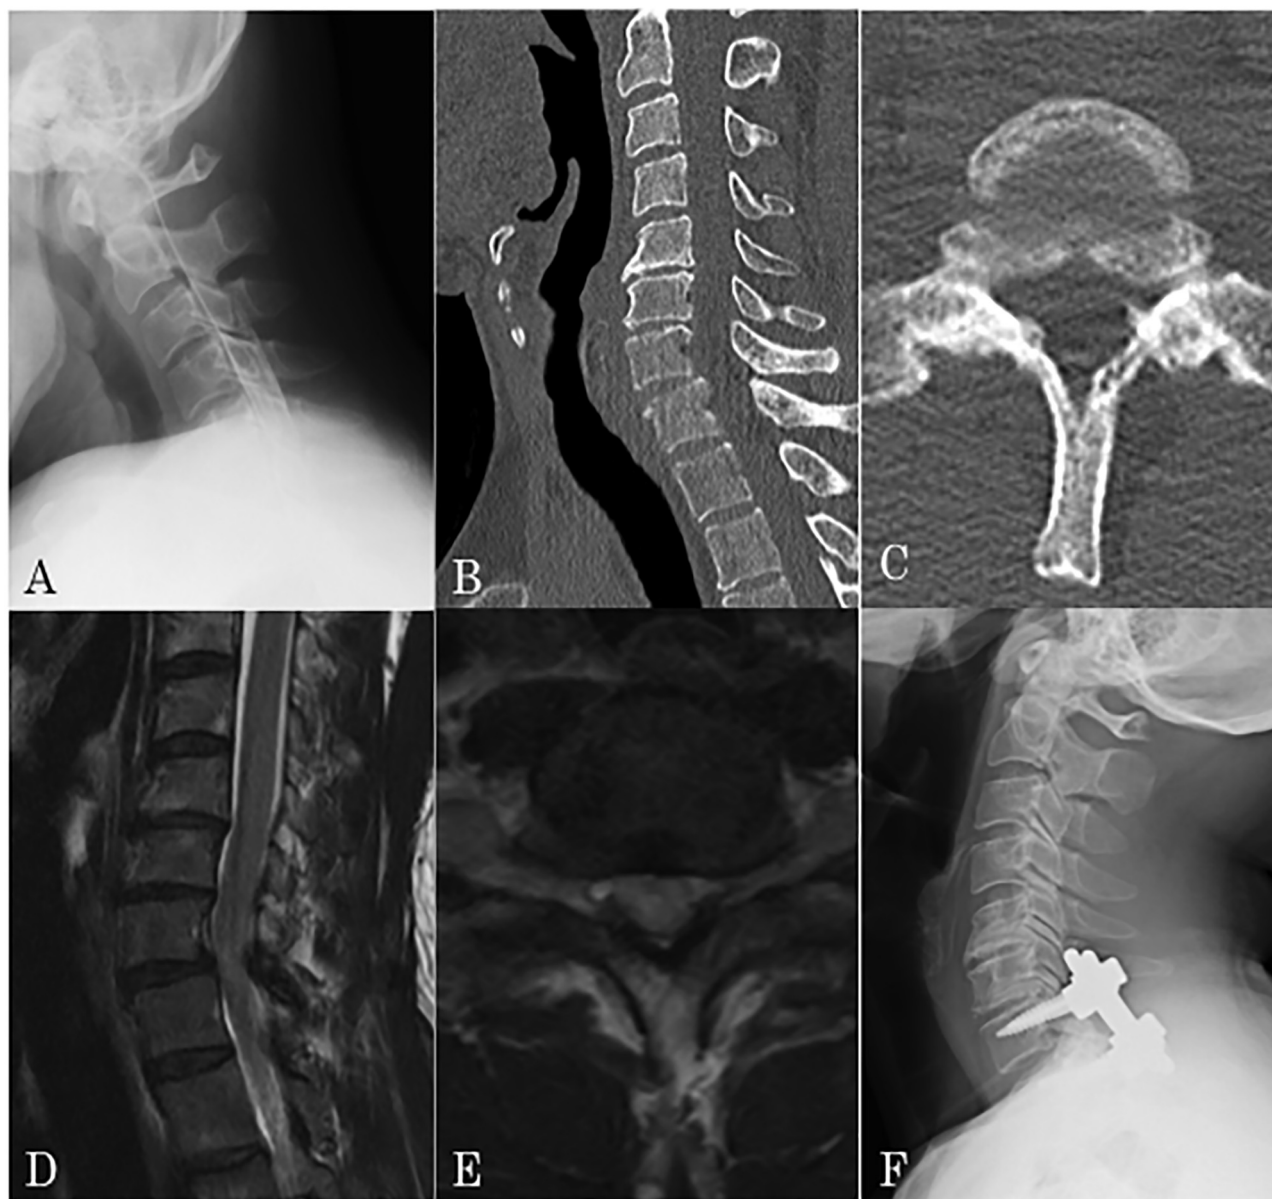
(A) Preoperative lateral view radiograph of cervical spine. Apparent abnormality could not be detected. (B) Sagittal reconstructed computed tomography (CT). (C) Axial image of CT-myelography at C7-T1 level. The spinal cord is compressed from both sides and shows atrophy. The C7-T1 facet joint indicates severe arthrosis with bony spur extending into the spinal canal. (D) Magnetic resonance imaging (MRI) T2-weighted sagittal plane. Spinal cord is compressed at C7-T1 level mainly from posterior. Note the intramedullary signal change at C7-T1 level. (E) Axial plane of MRI T2-weighted image. The spinal cord at C7 shows swelling with a region of slightly higher signal intensity. (F) Postoperative lateral view radiograph of cervical spine. C7-T1 laminectomy and facet fusion with posterior instrumentation were performed.
